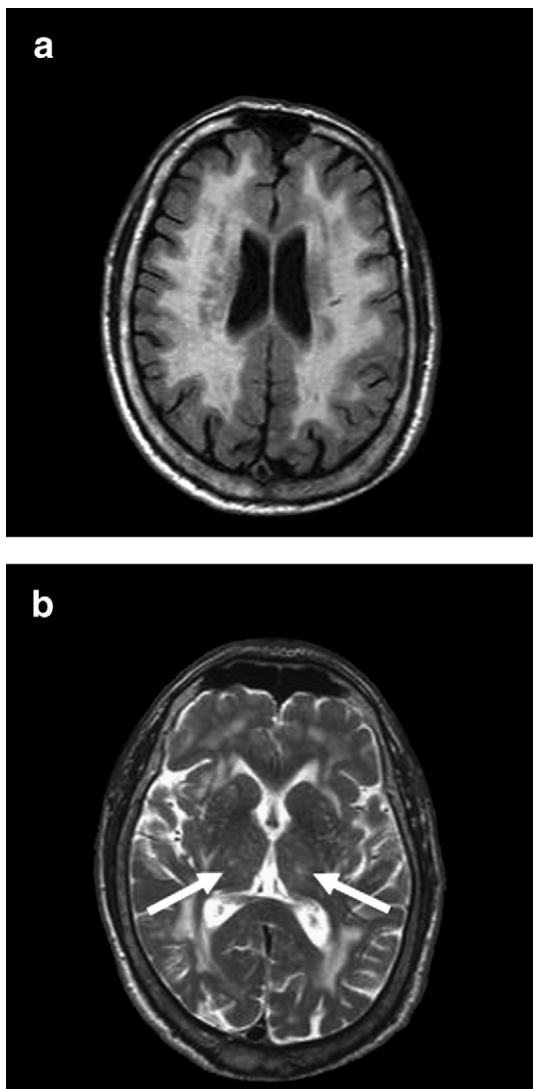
Cerebral MRI. Diffuse, symmetric, and confluent hyperintense lesions in the periventricular and deep white matter on an axial FLAIR image (a), and bilateral thalamic lacunar infarcts on an axial T2-weighted image (b, arrows).
